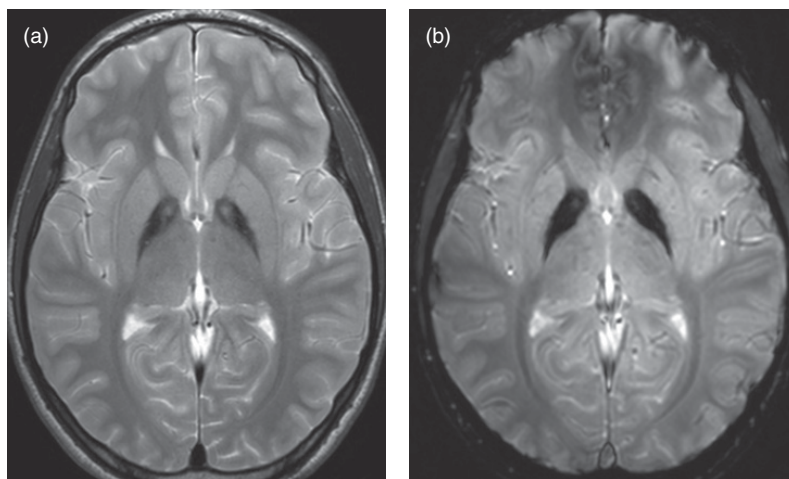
PKAN in a 15-year-old youth with disabling dystonia. (a) Axial T2-weighted imaging at the level of the basal ganglia demonstrates central globus pallidus T2 hyperintensity surrounded by T2 hypointensity. (b) On the axial T2* gradient echo sequence, there is intensification of the T2 hypointensity, typical for magnetic substances like iron.
